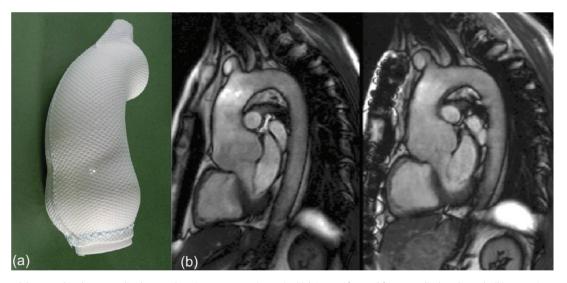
(a) Aortic model wrapped in the personalised external aortic root support (PEARS) which is manufactured from a medical grade mesh; (b) Magnetic resonance imaging of the aorta before (left) and after (right) insertion of the PEARS in the first patient [11].
